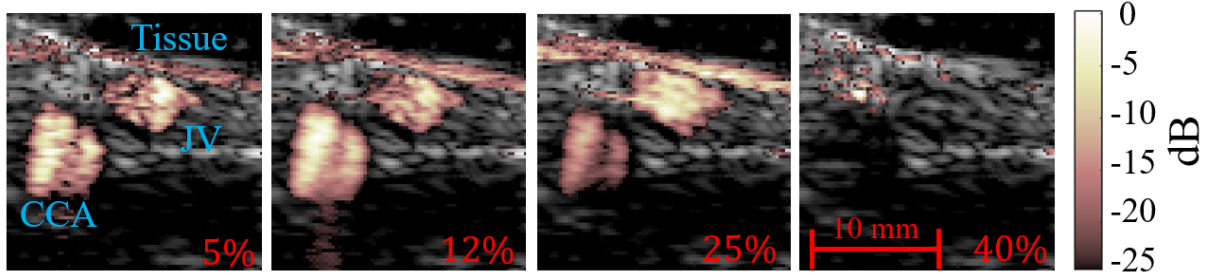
Demonstration of varying the threshold of acceptance for an *in-vivo* scenario showing the common carotid artery (CCA) and the jugular vein (JV). Power Doppler images were normalized relative to the maximum pixel intensity to better show the relative changes in flow and clutter pixel intensities. The threshold of acceptance (red values) is defined to include all singular components with an AUC that is within $x\%$ of the maximum measured component AUC. As the threshold is dropped, a more complete signal and less patchy signal is obtained up to the point where tissue components dominate the image.
